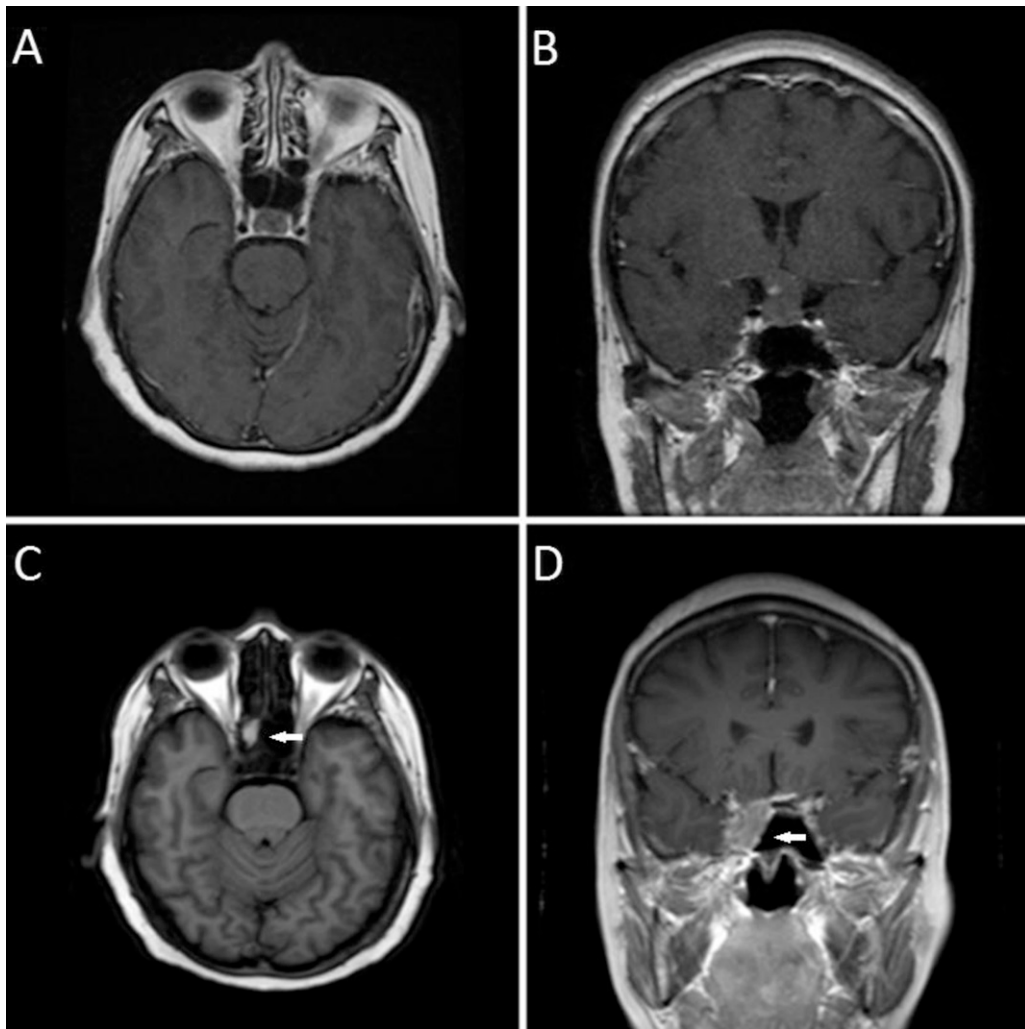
Preoperative contrast enhanced axial (A) and coronal (B) T1-weighted images showing one sellar mass with suprasellar extension and optic chiasm compression. Pathological report was pituitary adenoma. Axial native (C) and contrast enhanced coronal (D) T1-weighted images performed 4 months after transsphenoidal surgery showing absence of pituitary adenoma and the hyperintense lesion (white arrow) over right superior portion of sphenoid sinus.
